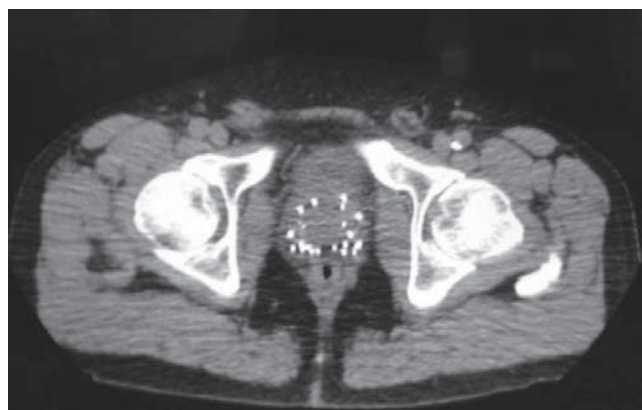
Post implant axial CT image of the prostate showing good peripheral seed loading.
